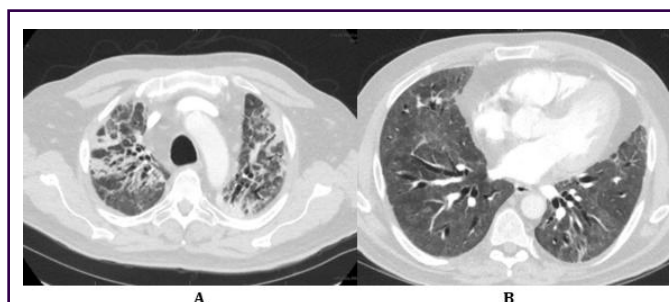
A: HRCT chest of upper lobes showing ground glass opacities (blue arrow) patchy opacities (green arrow); B: HRCT chest of lower lobes showing traction bronchiectasis (red arrow).
